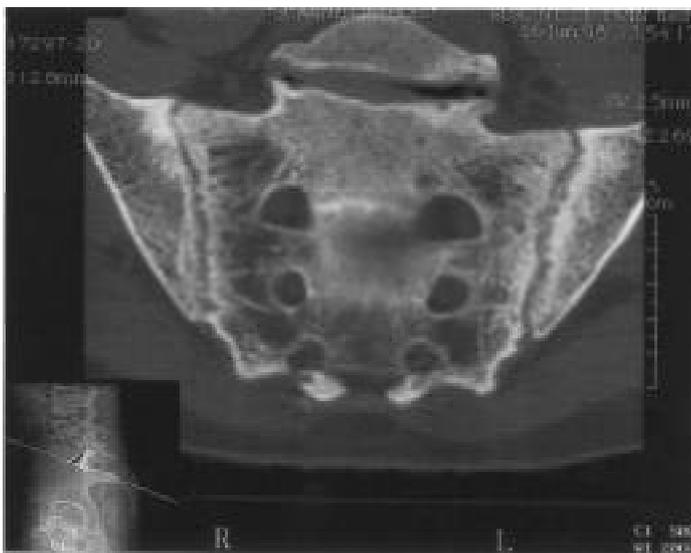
Computed tomography of the sacroiliac joints showing narrowing and irregularity but also a coarsened and sponge-like appearance.
